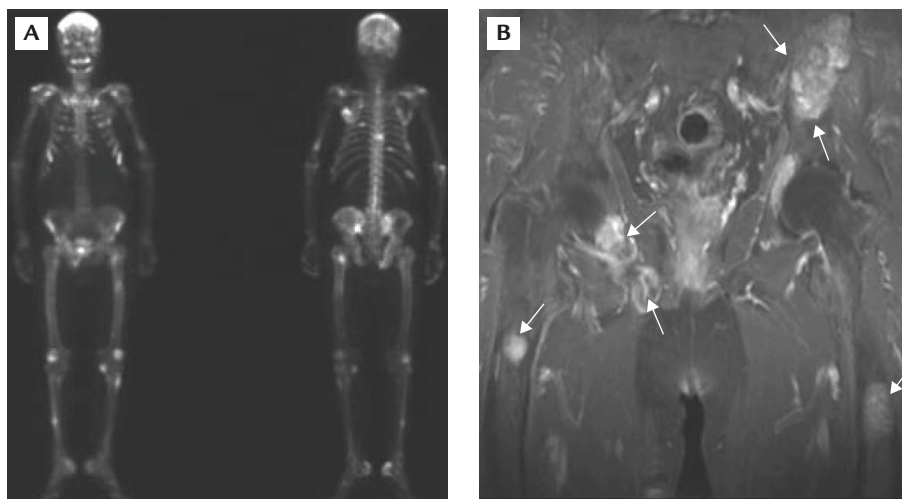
(A) Whole-body bone scan reveals increased uptake in the skeleton. (B) Magnetic resonance image is compatible with multiple osteolytic lesions (arrows).
